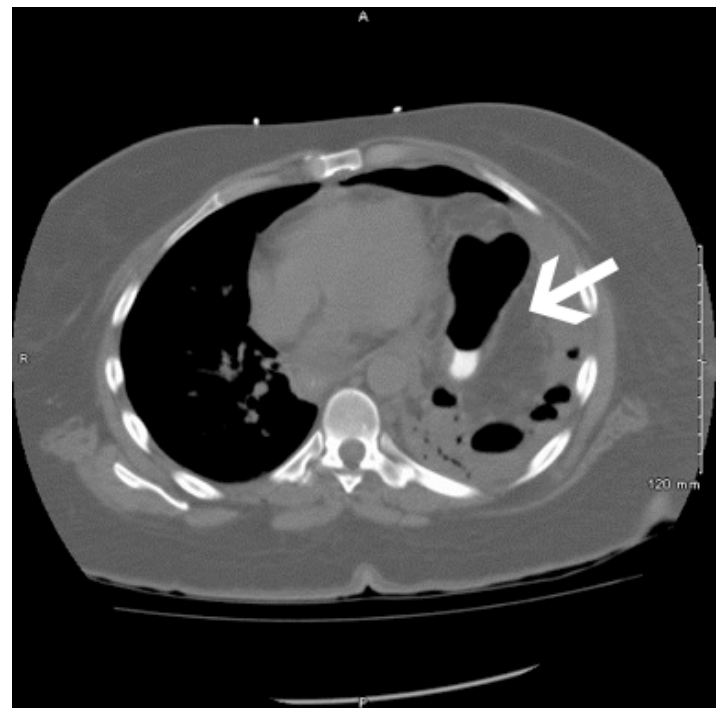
Axial computed tomography scan of the chest, demonstrating near complete atelectasis of the left lung along with a loculated hydropneumothorax with multiple air pockets, suggestive of empyema.
